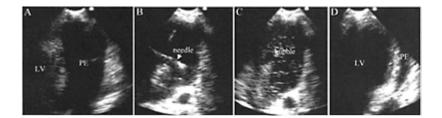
Portable echocardiography during pericardiocentesis. (A) A large amont of pericardial effusion (PE) was seen. (B) Under guidance of SonoHeart, a needle was inserted into the pericardial space. (C) To determine the location of the needle, a small amount of agitated saline was injected through the needle and the bubbles were seen. (D) After drainage, the amount of pericardial effusion was
